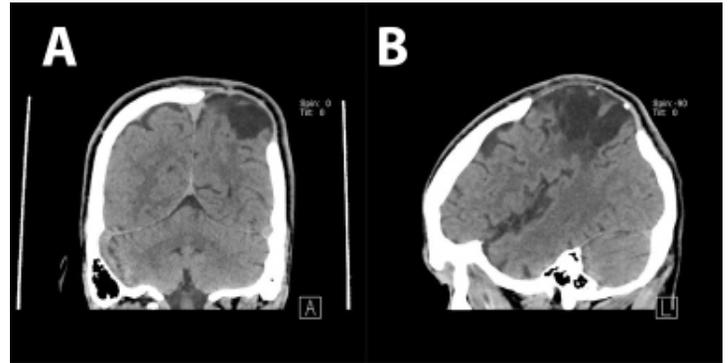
Anterior and Posterior CT Views Before Surgery
